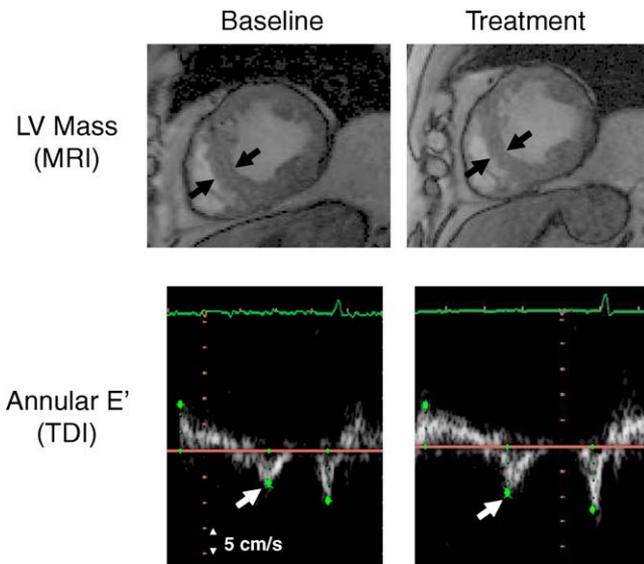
Left ventricular (LV) mass was measured by magnetic resonance imaging (MRI). After treatment, LV mass was decreased. The black arrows indicate the thickness of the LV septum. The peak early diastolic velocity (E′) of the mitral annulus was measured by tissue Doppler imaging. After treatment, E′ decreased (white arrows).
